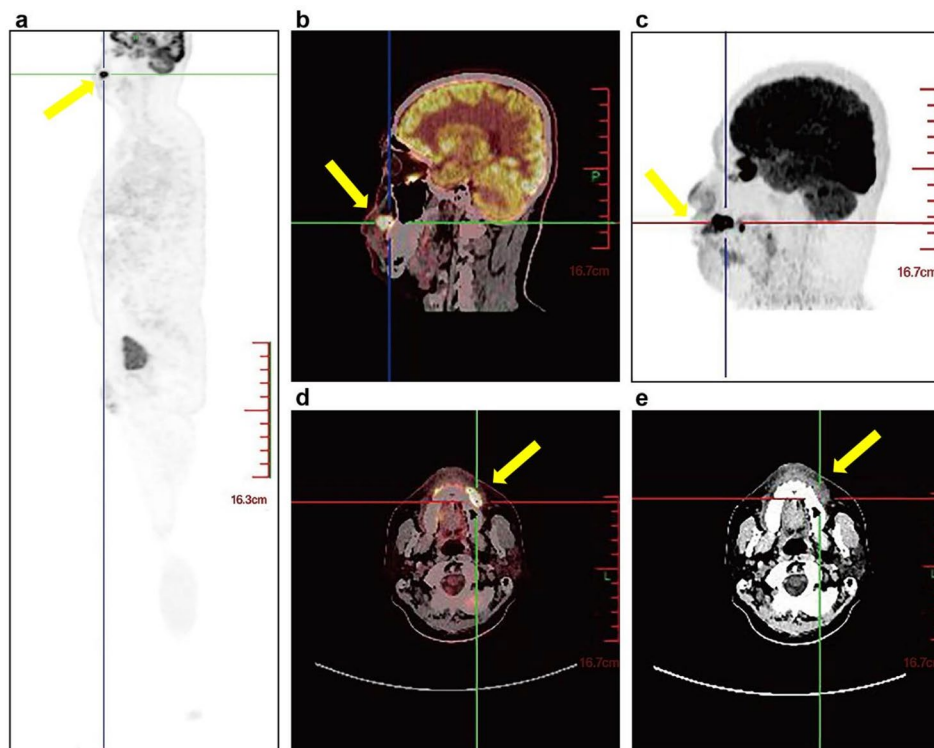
PET/CT of the hypermetabolic soft tissue lesion in the left upper lip. a Whole-body sagittal PET image showing a focal area of increased FDG uptake in the left upper lip (yellow arrow). b Sagittal PET/CT fusion image demonstrating the hypermetabolic soft-tissue mass in the left upper lip, measuring approximately 2.7 cm × 1.5 cm (SUVmax = 19.8). c Sagittal PET image of the head and face showing localized abnormal glucose metabolism in the left upper lip region. d Axial PET/CT fusion image showing the left upper lip lesion with markedly increased FDG uptake. e Corresponding axial CT image of panel (d), revealing a soft-tissue mass with heterogeneous density (yellow arrow)
